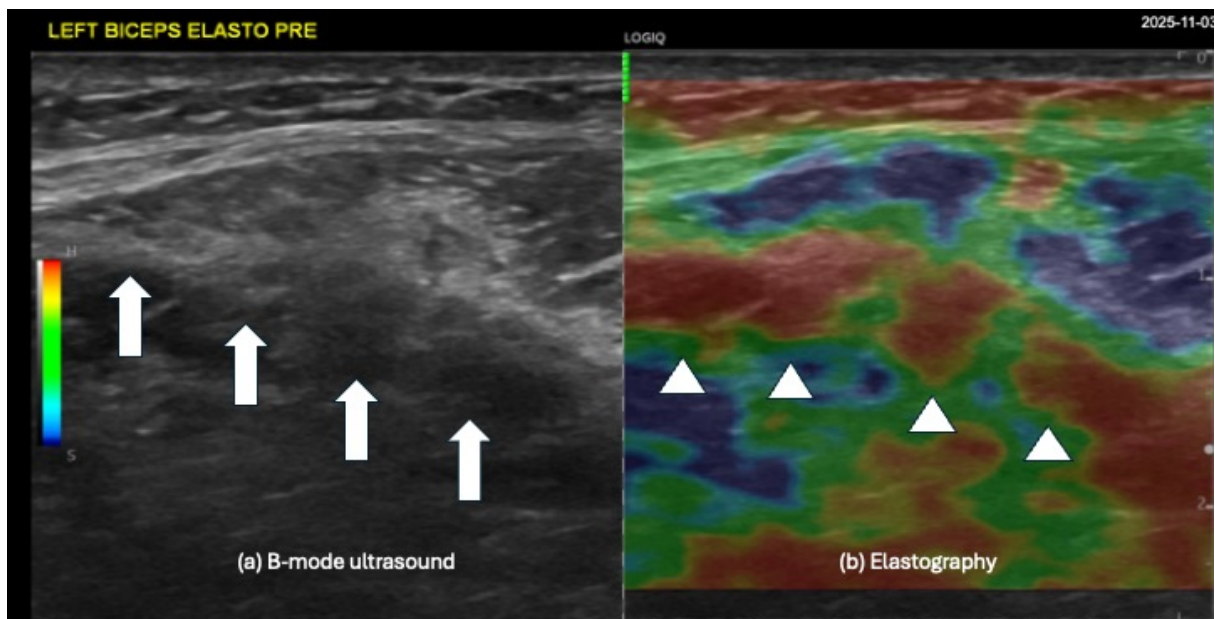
Ultrasound images of left forearm showing (a) diffuse fibrosis of fascia and (b) perineural fibrosis around the radial nerve just inferior to the radial groove.
